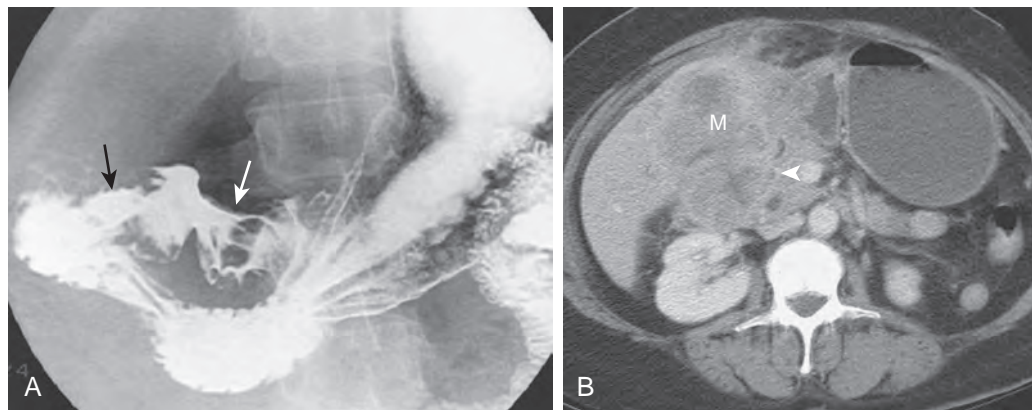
Gallbladder carcinoma invading the stomach and duodenum. A. Barium study shows narrowing and ulceration of the postbulbar duodenum (*black arrow*) and distortion of the distal gastric antrum (*white arrow*) because of invasion by tumor. B. CT scan in the same patient shows an advanced carcinoma of the gallbladder (M) directly encasing and narrowing the descending duodenum (*arrowhead*). Also note tumor invading the distal stomach and infiltrating the peritoneal cavity.
